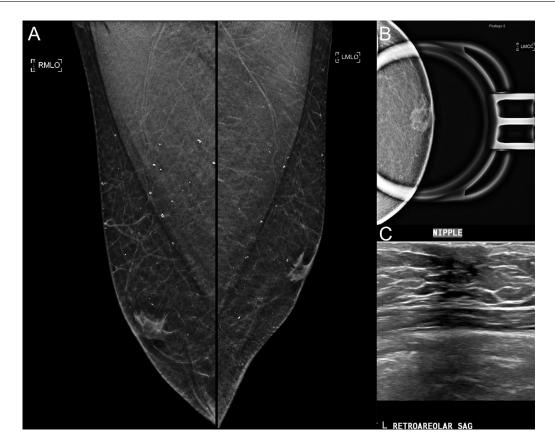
Benign initial mammogram and ultrasound workup for bloody left nipple discharge. Bilateral mammogram demonstrated mild bilateral symmetric gynecomastia without suspicious findings (A). Mammographic magnification view of the left retroareolar breast demonstrated scattered benign-appearing calcifications without discrete suspicious group (B). Targeted left retroareolar breast ultrasound demonstrated normal retroareolar glandular tissue consistent with gynecomastia without suspicious sonographic finding (C).
